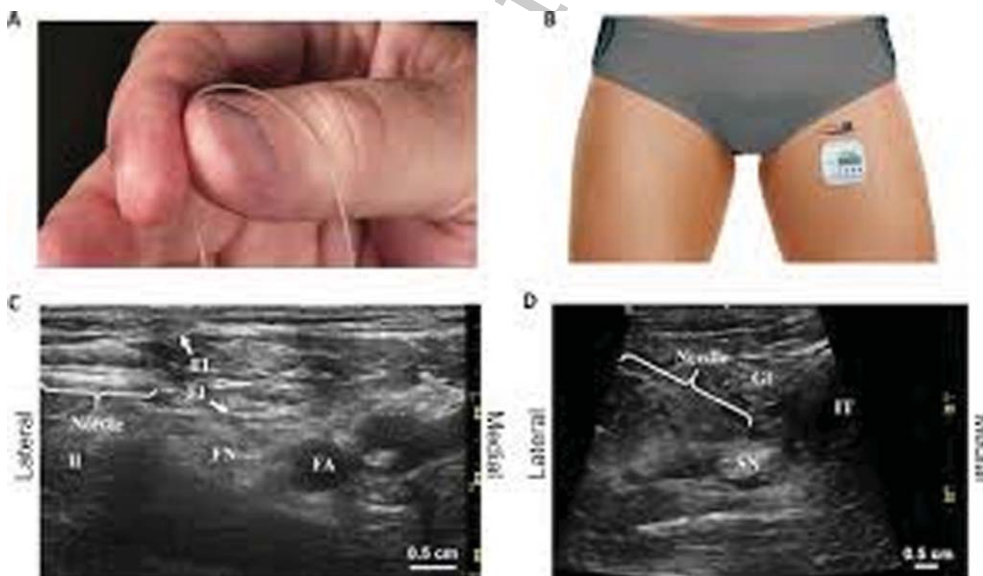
PNS leads and Ultrasound Appearance.
